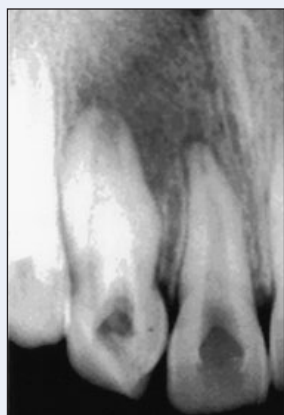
Preoperative radiograph of maxillary lateral incisor showing Type 3 dens invaginatus with periapical radiolucency.
